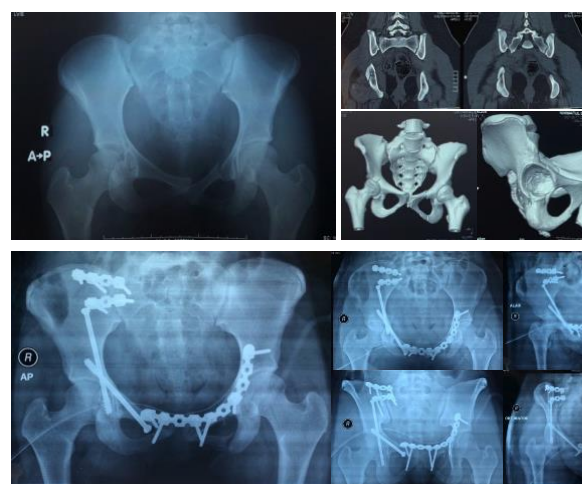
Female, 17 years old, M.V.A. being hit by the truck (a) Initial AP Xray showing disruption at the right sacroiliac joint, suspected fracture line at right acetabulum and left pubic rami disruption. (b) CT images showing vertical translation of right hemipelvis, transverse acetabular fracture. (c) Post-operative images after ORIF at right SI Joint and left pubic rami and both column acetabular screw for the transverse fracture.
